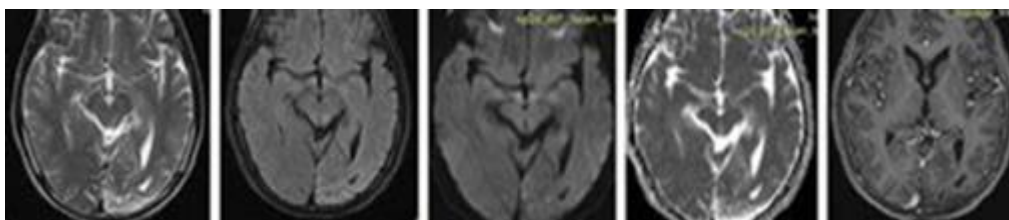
A brain MRI showing polymicrogyria
